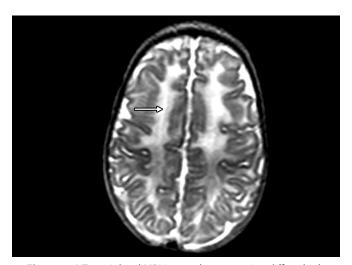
A T2 weighted MRI image demonstrating diffuse high signal intensity in the white matter (arrow)
